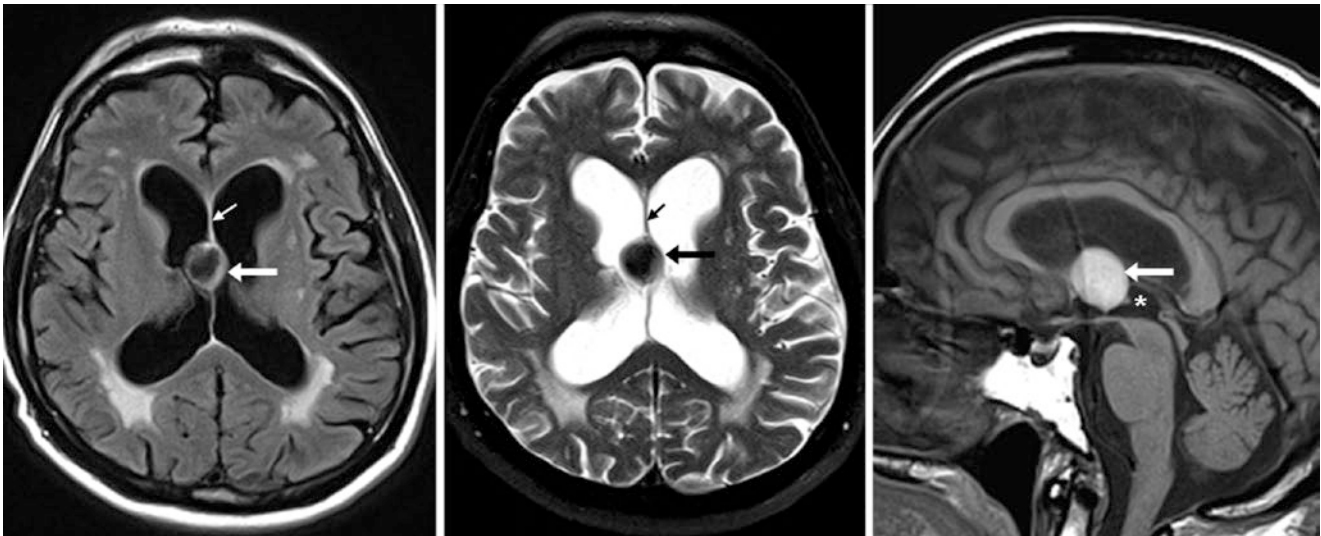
Comparison case of a third ventricular colloid cyst. A 74 year old had a cystic mass (*arrows*) within the roof of the third ventricle (*), with dark signal on FLAIR (*left*) and T2WI (*middle*) and was bright on noncontrast sagittal T1WI (*right*). The septum pellucidum is normal
